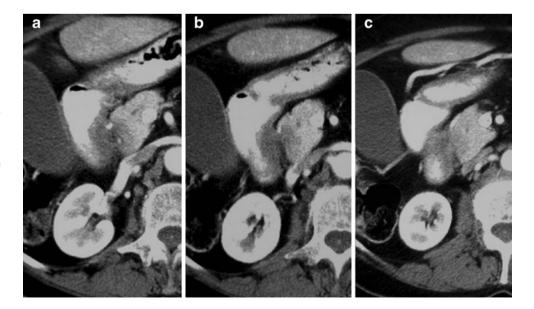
Duodenal adenocarcinoma. CT scan shows a solid intraluminal soft-tissue mass in the medial wall of the second duodenal portion with transmural invasion into the pancreatic head
